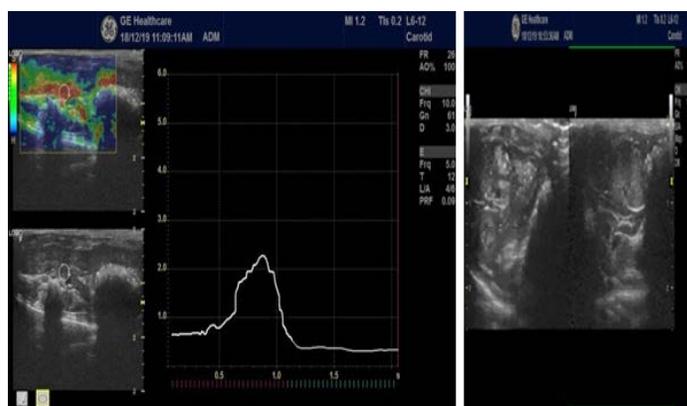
Elastography and Ultra sonography of C300. Liver size: 1.6cm. Elastographic score (pKa-1.9)
